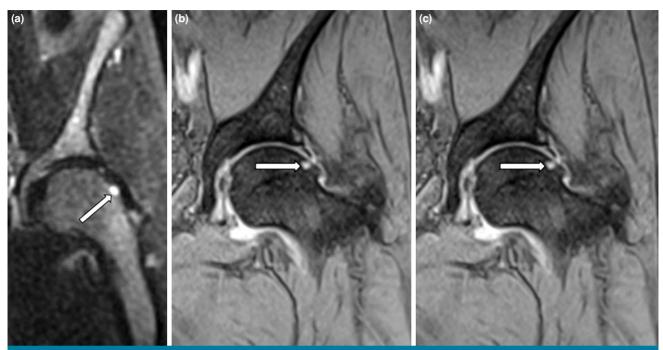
Magnetic resonance imaging of a left hip showing a subchondral cyst in the femoral head neck junction (arrows). (a) Coronal T1-weighted sequence, (b) coronal T1-weighted sequence, (c) axial T1-weighted sequence.
